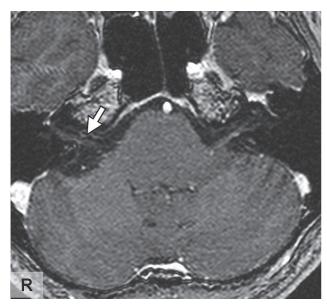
T1-weighted MRI with gadolinium of the IAC. A T1-weighted magnetic resonance (MR) image with gadolinium shows no enhancement of the lesion in the right internal auditory canal (IAC) (arrow). R, right.
